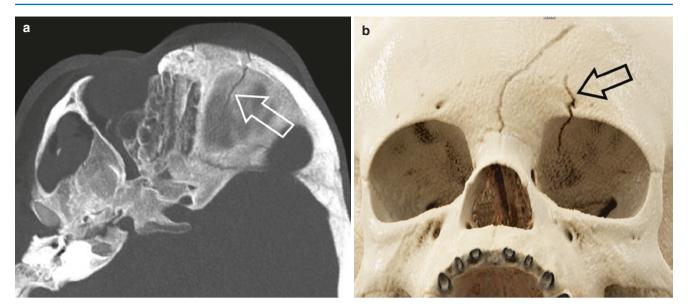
CT of a 3-year-old girl who fell from the stairs. (a) MPR MIP image and (b) 3D reconstruction show fracture line (arrows) running through the orbital rim. Also, note another fracture line in the frontal bone ending at the frontanasal suture and the monocle haematoma
